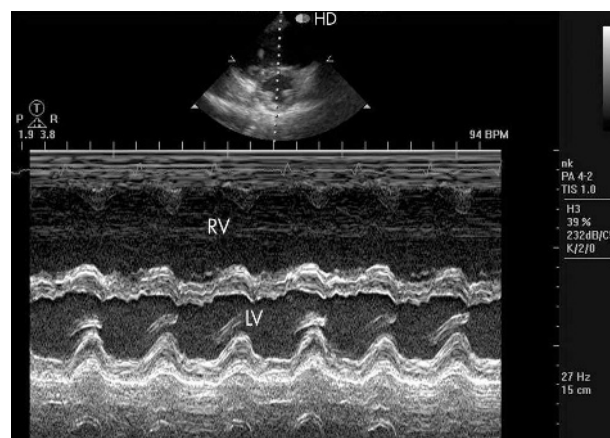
M mode echocardiogram of the same patient shown in fig 5. There is paradoxical septal motion, a sign of RV volume overload. RV enlargement relative to the left ventricle is evident. LV, left ventricle; RV, right ventricle.
